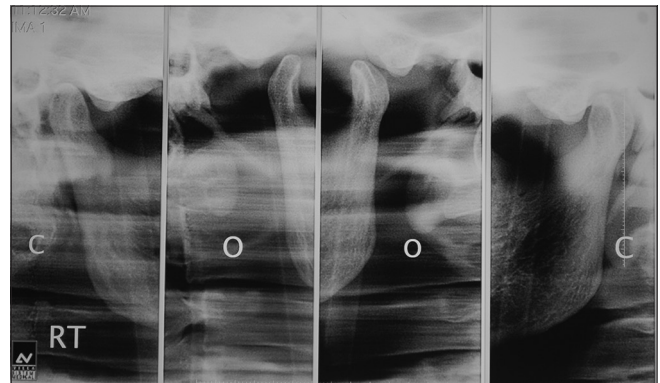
Double lateral temporomandibular joint radiograph showing bilateral condyles traversing ahead of articular eminence
